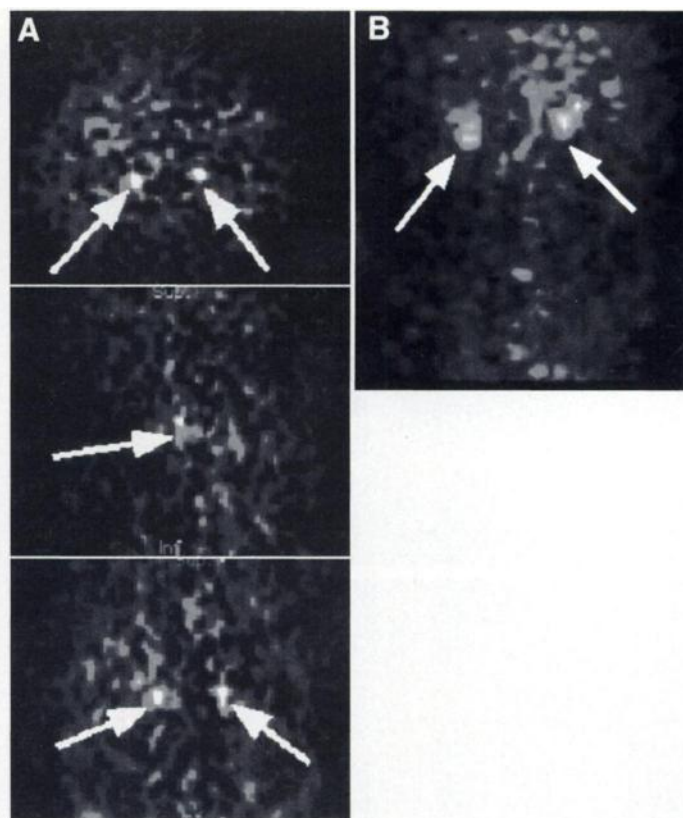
(A) SPECT image of the abdomen in transaxial, sagittal and coronal planes shows bilateral foci of increased tracer uptake in the regions of the adrenal glands (arrows). (B) Reprojected volume-rendered image reconstructed from the transaxial image confirms these abnormalities (arrows).
